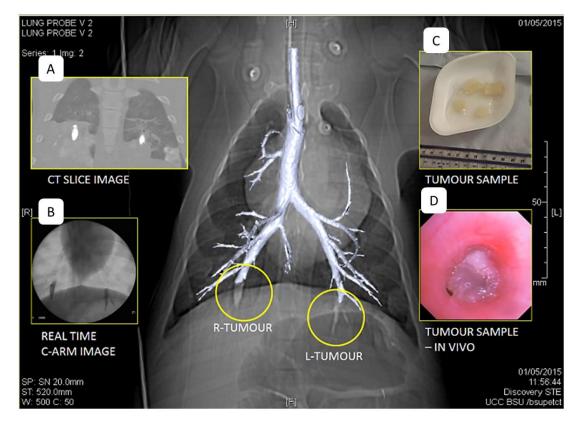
Tripe tumour models visible in lower right and left lobes (main) with overlaid images of a CT slice through the models (A), a C-arm X-ray image taken in real time while placing the models (B), and images of the tripe modes prior to insertion and positioned *in vivo* (C and D).
